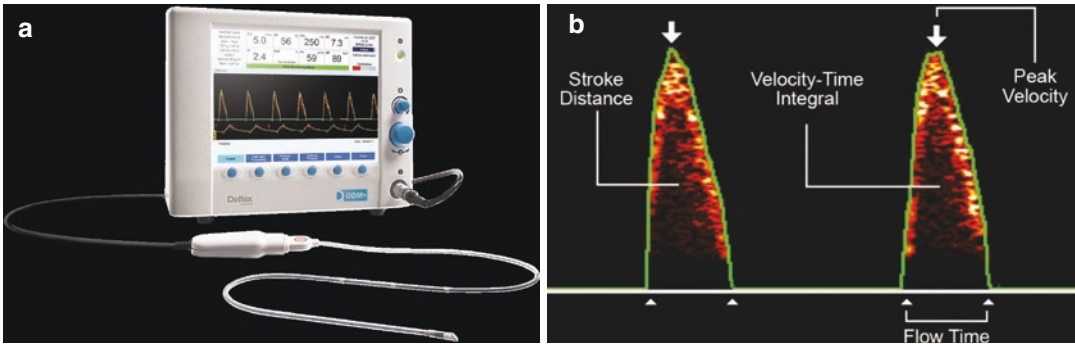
Deltex Medical esophageal Doppler system (a) with a corresponding velocity time integral trace (b) from <https://www.deltexmedical.com>. (Used with permission of Deltex Medical Limited)
